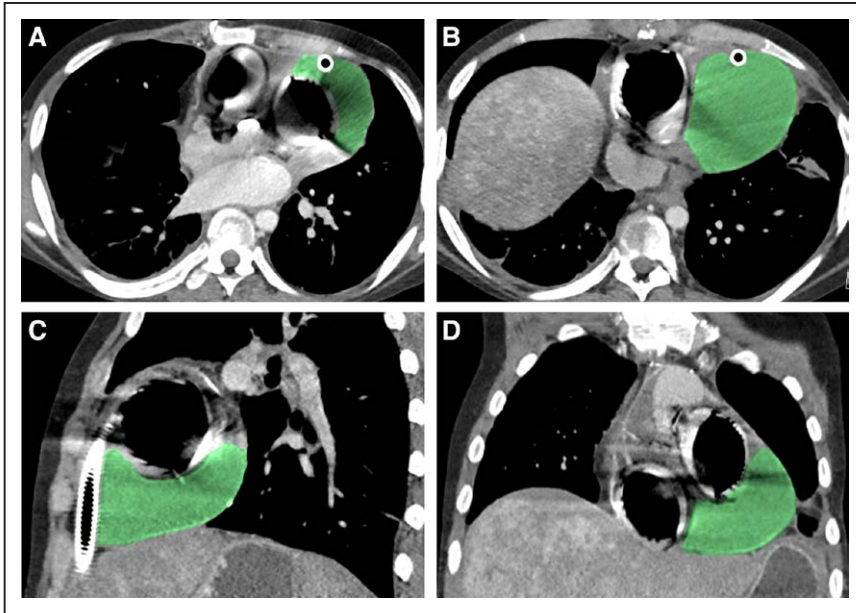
Contrast-enhanced chest computed tomographic (CT) images after implantation of the 50cc SynCardia total artificial heart. Superior axial (A) and inferior axial (B) views demonstrate placement of a small breast implant (green) within the pericardial sac between the 2 components of the artificial heart. Note that the implant does not deform the normal structure of components and drive line. Coronal (C) and sagittal (D) views demonstrate that the breast implant appropriately fills the pericardial space with no changes in expected confirmation of the pericardium.
